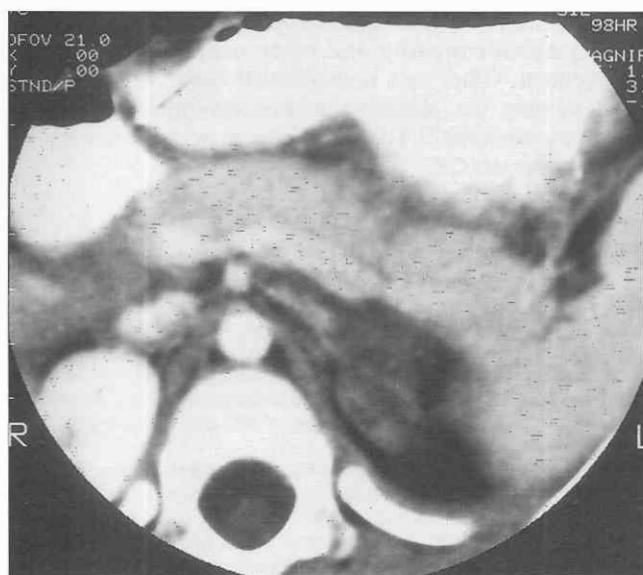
Pancreatic laceration with minimal separation of fracture fragments. Magnified CT scan through the pancreas of a patient injured in a motor vehicle accident shows a laceration through the body of the pancreas with minimal separation of the fracture fragments.
